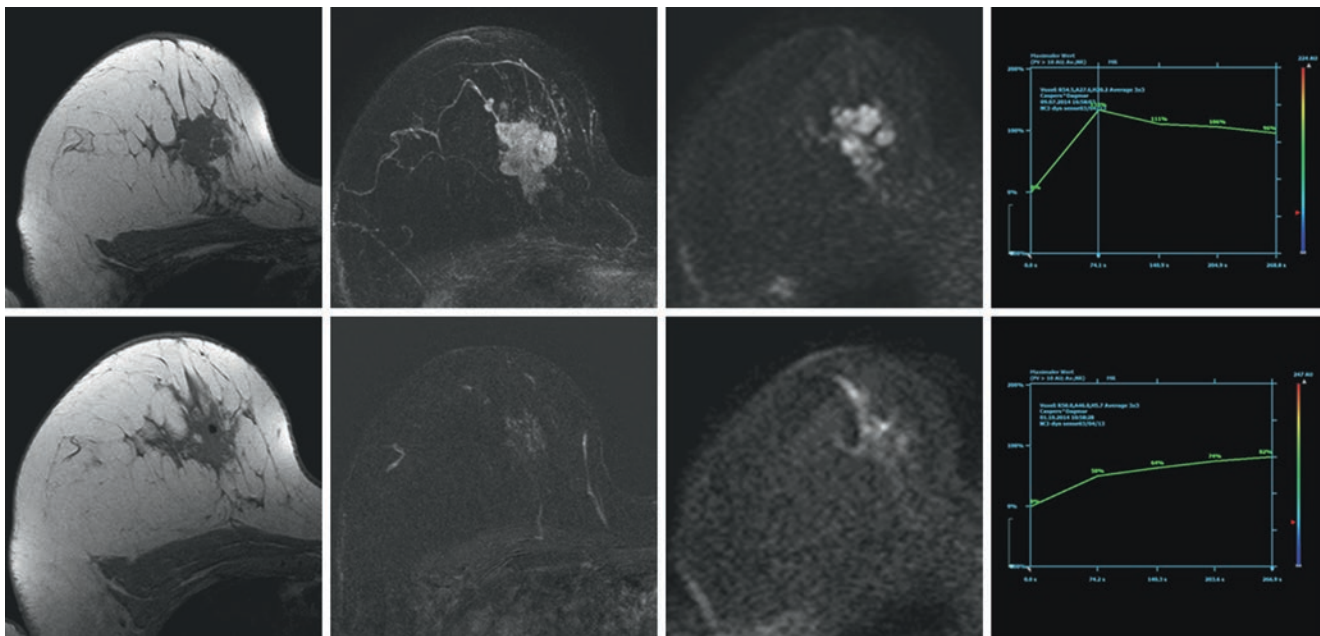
Utility of diffusion-weighted imaging to complement DCE-MRI for response assessment. *Upper row*, baseline study. *Lower row*, study after completion of neoadjuvant treatment. *Left column*, pre-contrast T1-weighted images. *Middle left column*, contrast-enhanced subtracted images. *Middle right column*, corresponding DWI at $b = 800$.
